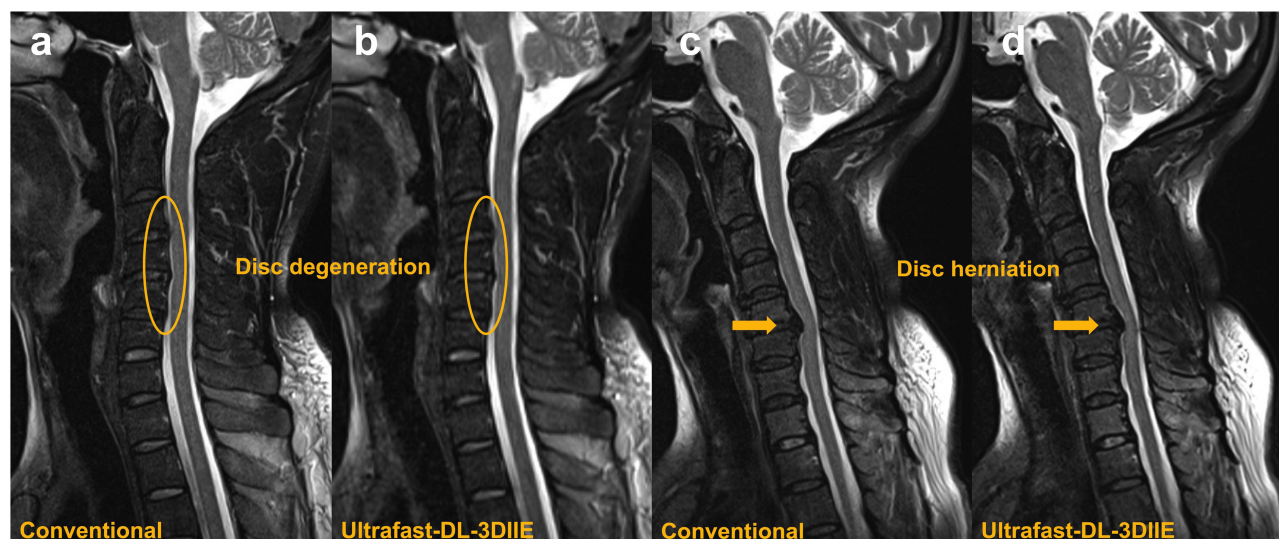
Sagittal T2-weighted images of a participant with disc degeneration (C3-4, C4-5 and C5-6 discs, Orange ellipses), were obtained from both conventional (a) and ultrafast-DL-3DIIE (b) protocols. And sagittal T2-weighted images of a participant with disc herniation (C5-6 disc, Orange arrows), obtained from both conventional (c) and ultrafast-DL-3DIIE (d) protocols.
